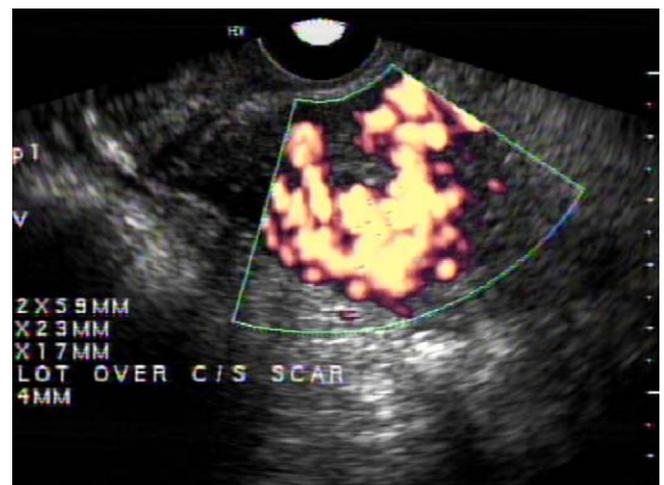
Transabdominal ultrasound reveals a strong signal of blood flow in the uterine myometrium, suggesting the possibility of placenta increta.
